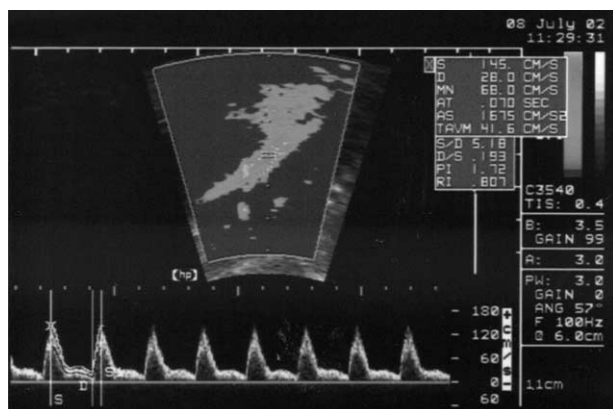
Doppler velocimetry in the aorta (suprarenal segment), showing the wall filter, insonation angle, site of insonation and measurement of peak systolic velocity (S), end-diastolic velocity (D) and resistance index (RI).
